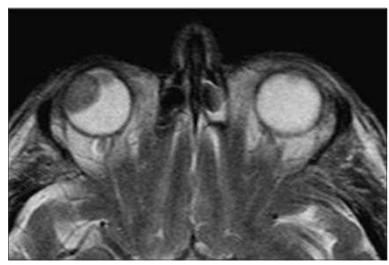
T2-Weighted Magnetic Resonance Image of Ciliochoroidal Melanoma Showing Hypointensity of Intraocular Tumor Compared With the Bright (Hyperintense) Vitreous.
